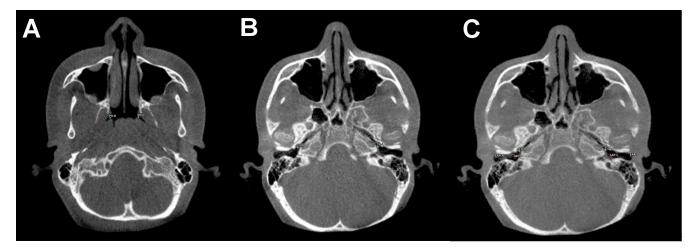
Axial cone-beam computed tomography (CBCT) slices
